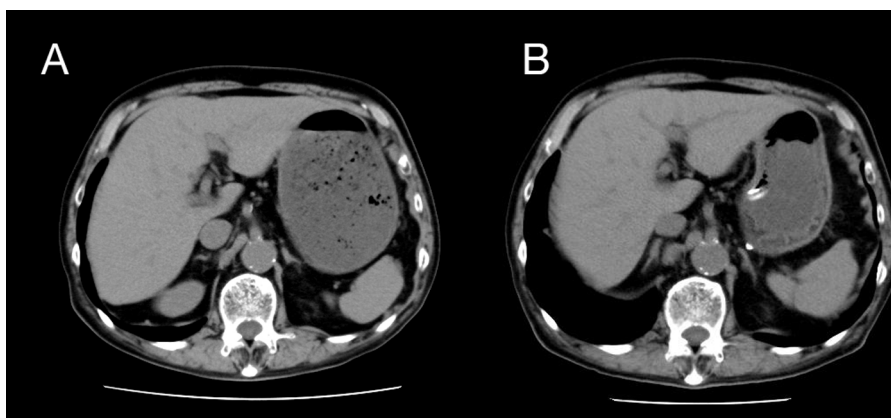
(A) A computed tomographic scan showing the retention of a large volume of gastric contents on the first hospital day (502 mL). (B) On the fourth hospital day, the volume of gastric contents had decreased, but a large volume of food debris remained (156 mL).
